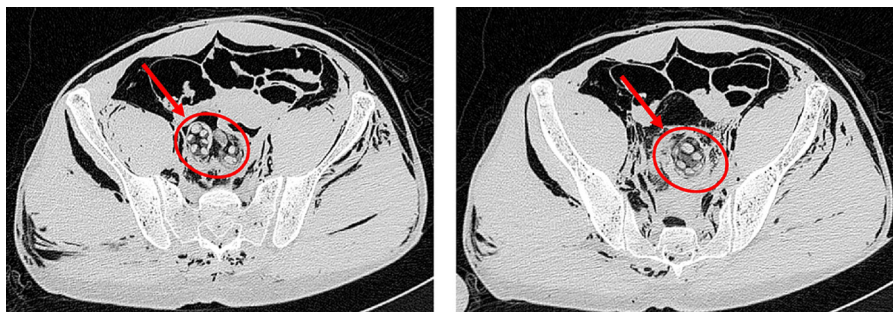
Postmortem computed tomography. Drug packages composed by multiple spherical or oval hyperdense packages at the recto-sigmoid junction.
